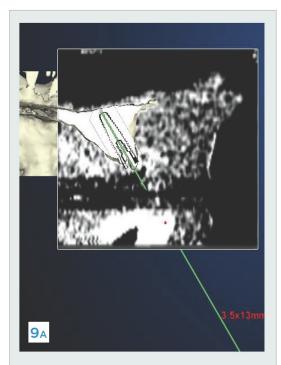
AND FIGURE 10. This CBCT allowed the placement of implants just into the nasal floor without disrupting the nasal area. A guide was used to ensure the inferior alveolar nerve was not damaged.
